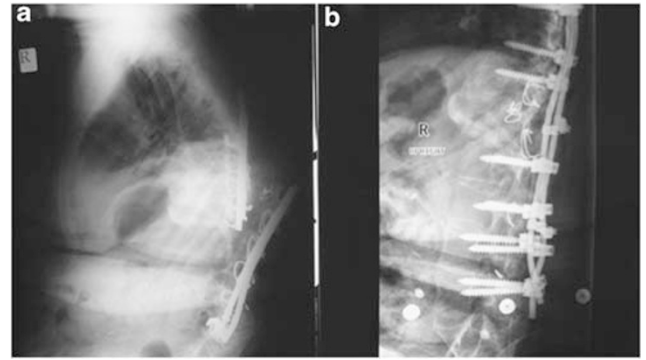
Radiographs of case 2 before (a) and after (b) surgical repair.
